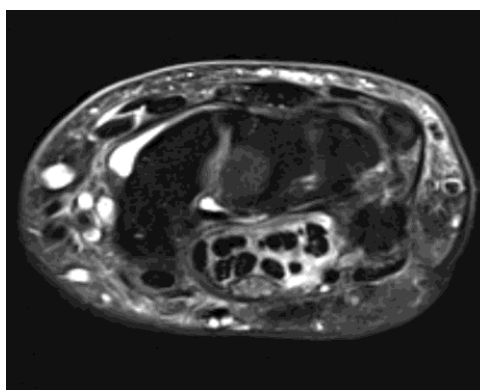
Axial T2-weighted fat-suppressed image at the level of the carpal tunnel showing fluid surrounding the flexor tendons, indicative of flexor tenosynovitis. The resultant increase in tunnel contents leading to median nerve compression. These findings are suggestive of Carpal tunnel syndrome.
